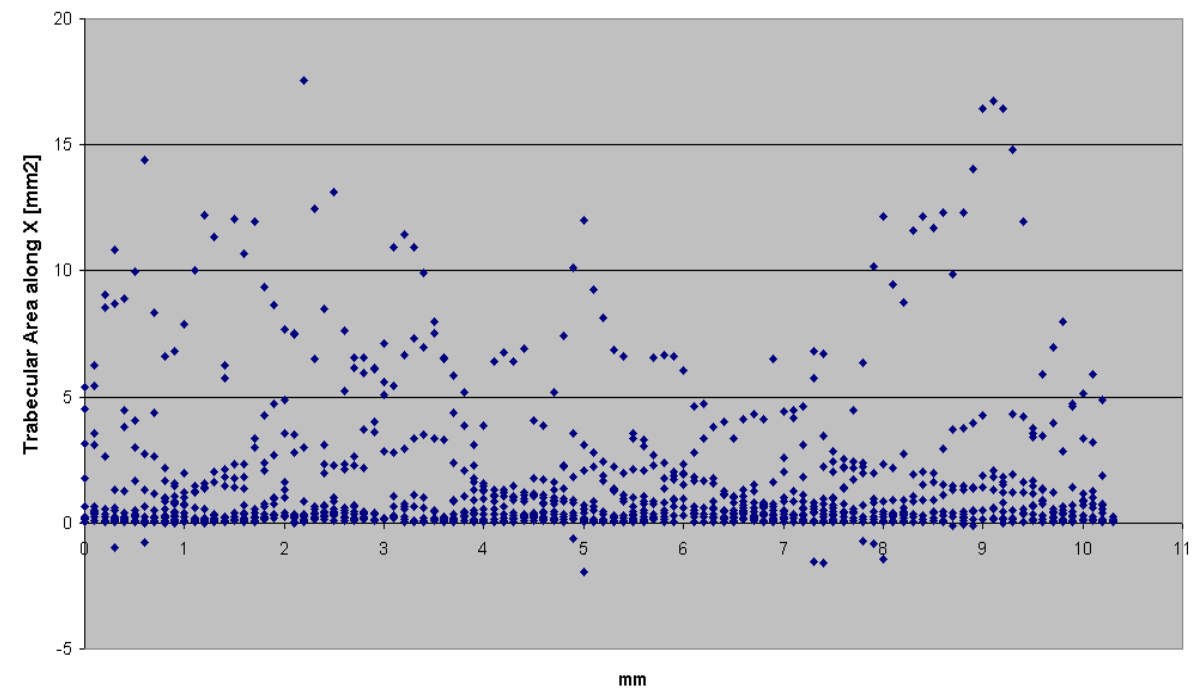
Cubic  $\mu$ CT sample: trabecular area distribution along  $X$
